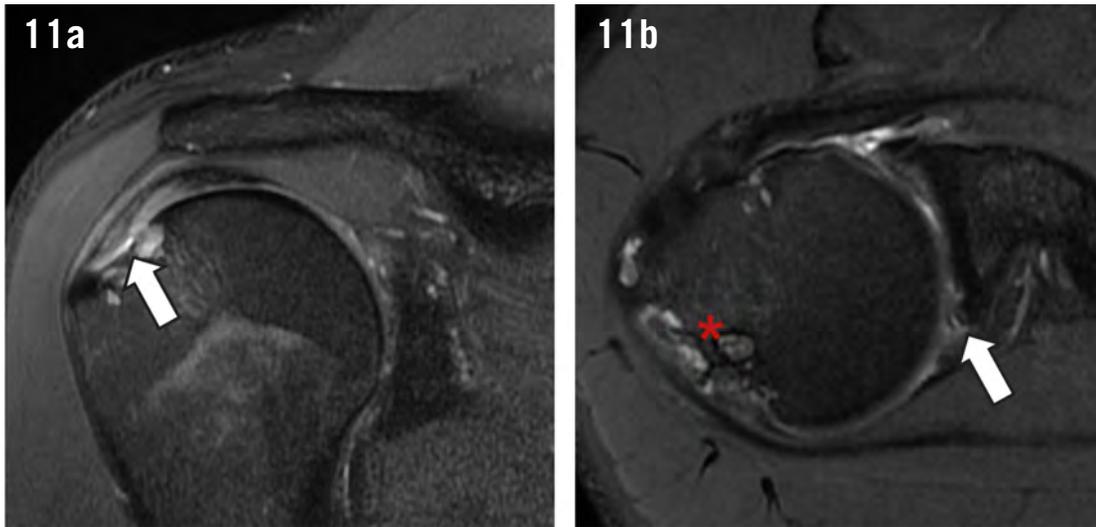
Magnetic resonance imaging of a shoulder with internal impingement syndrome. Sagittal (a) and axial (b) T2 weighted images with fat saturation depicting a tendinopathy and a partial-thickness tear of infraspinatus tendon near the humeral attachment (arrow in a), osseous remodeling and cysts in the posterosuperior aspect of the humeral head (asterisk) and an injury in the posterosuperior labrum (arrow in b).
